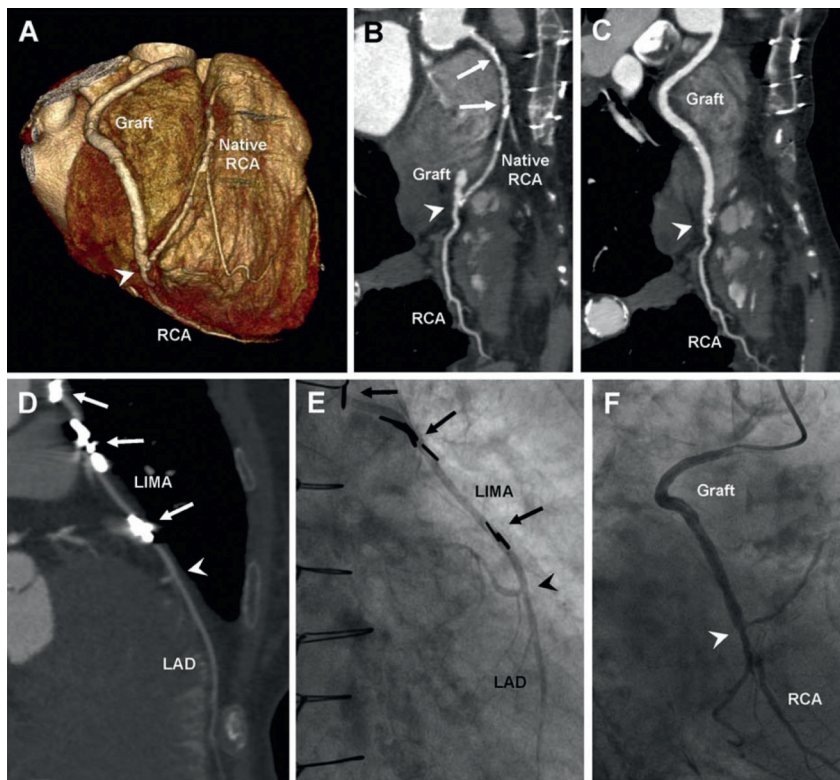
CTA of a patient in a 77-year-old woman with a history of venous and arterial CABG. A three-dimensional volume rendered reconstruction of the heart is shown in Panel A. A single venous graft is identified with an anastomosis on the distal RCA (arrowhead). Panel B shows a curved multiplanar reconstruction of a heavily diseased native RCA, with severely calcified and non-calcified lesions proximal to the graft anastomosis (arrows). A curved multiplanar reconstruction of a patent venous graft is depicted in Panel C. Although diffuse atherosclerosis with calcified plaque is visible in the venous graft, no significant luminal narrowing is observed. Furthermore, a patent anastomosis with the RCA is present (arrowhead) with good distal run-off. In Panel D, a LIMA graft is shown with a patent anastomosis on the mid-LAD. The graft appears to be patent with good distal run-off, although high-density artefacts caused by metal clips locally hamper graft visibility. Patency of the venous and LIMA grafts and anastomoses (arrowheads), as well as good distal run-off in the grafted vessels was confirmed on ICA (Panels E and F). CTA: computed tomography coronary angiography; ICA: invasive coronary angiography; LAD: left anterior descending coronary artery; LIMA: left internal mammary artery; PCI: percutaneous coronary intervention; RCA: right coronary artery
